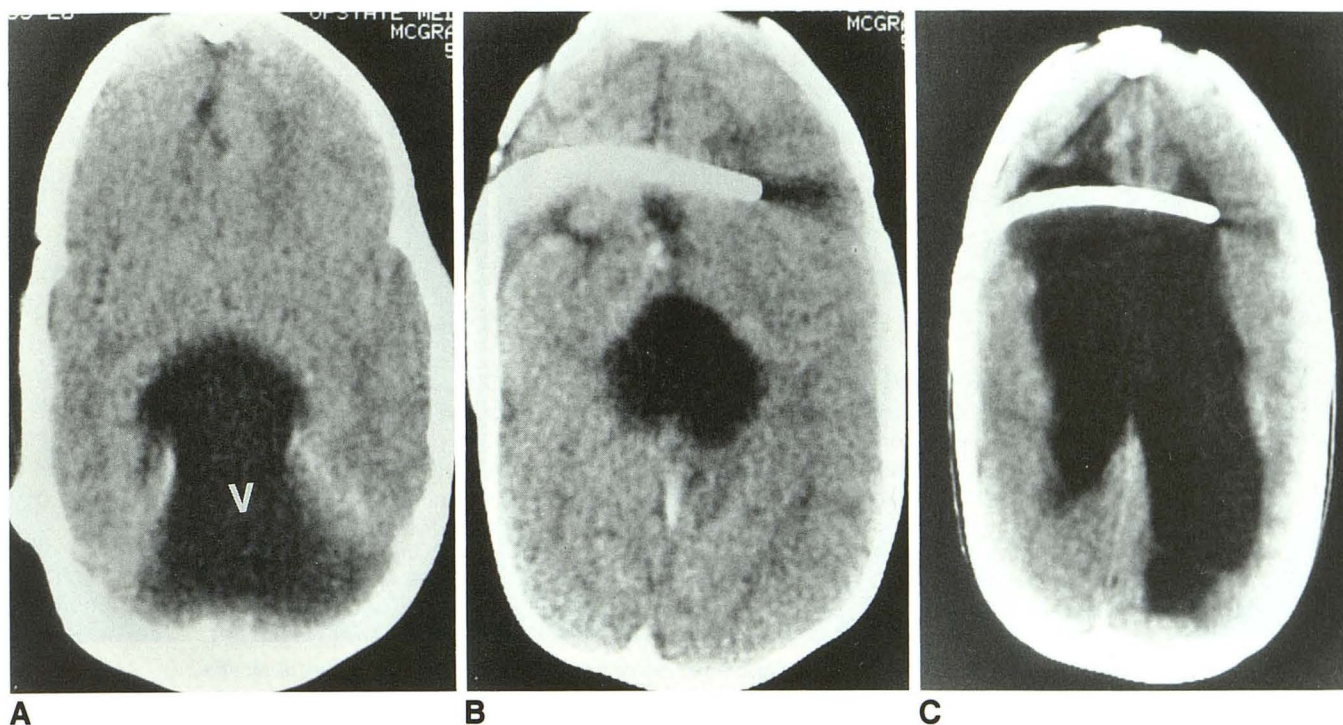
Trapped fourth ventricle (case 1). CT scans show the keyhole appearance of an encysted fourth ventricle (v) which occupies the entire posterior fossa and protrudes superiorly through the tentorial notch (A). It compresses the lateral ventricles (B) causing the CSF in the compressed lateral ventricles to escape through a patent shunt, resulting in ventricular collapse or overshunting. After cyst-peritoneal shunting, the encysted fourth ventricle has been effectively decompressed. Once the pressure on the lateral ventricles was reduced, they had expanded beyond the expected size (C) erroneously suggesting shunt obstruction by CT criteria while clinically the patient was doing well.
